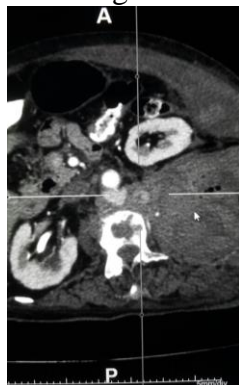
CT image axial cut of pseudoaneurysm
